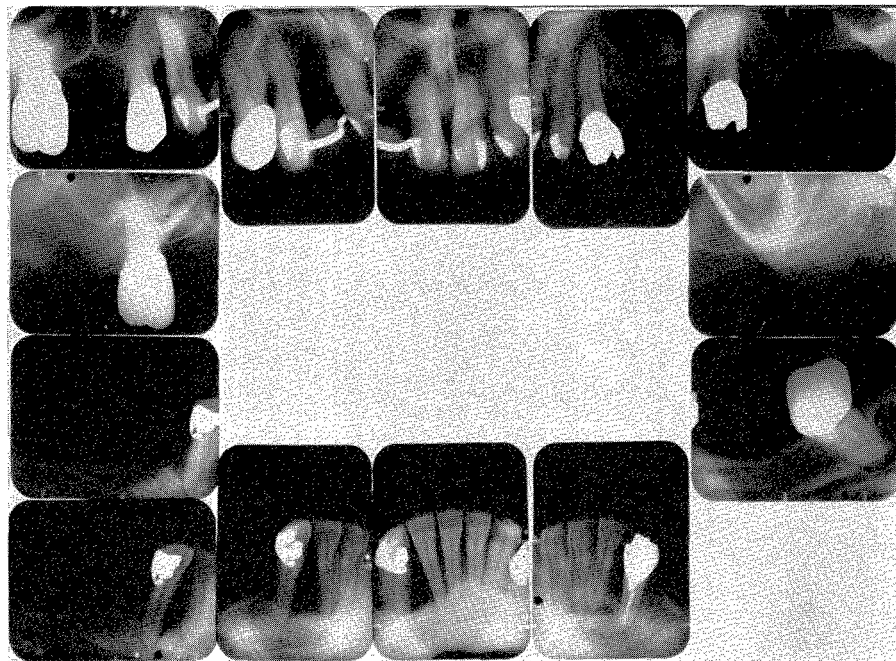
Roentgenograms taken in December, 1948, reveal the advanced periodontal disease associated with several teeth. The patient was then 45 years old.
